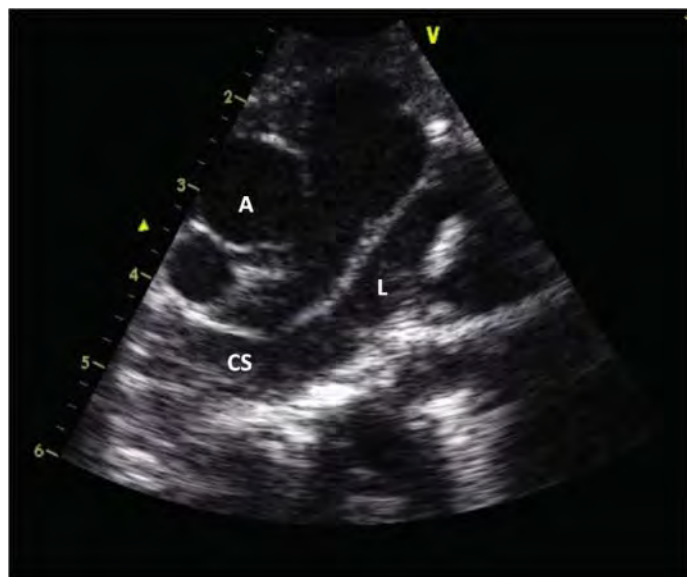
Echocardiographic image of the left superior vena cava (SVC) in a patient with L-transposition and a ventricular septal defect (VSD). The left SVC (L) connects to the dilated coronary sinus (CS).
